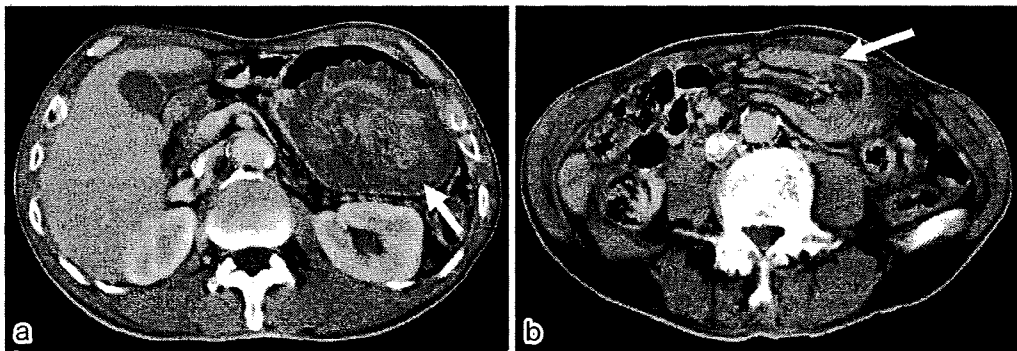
(a) Enhanced CT showed a distended stomach with an intragastric filling by bowel loops (arrow). (b) Mesenteric fat and vessels were followed into the intussusception with central area of fat density and vessels (arrow).
